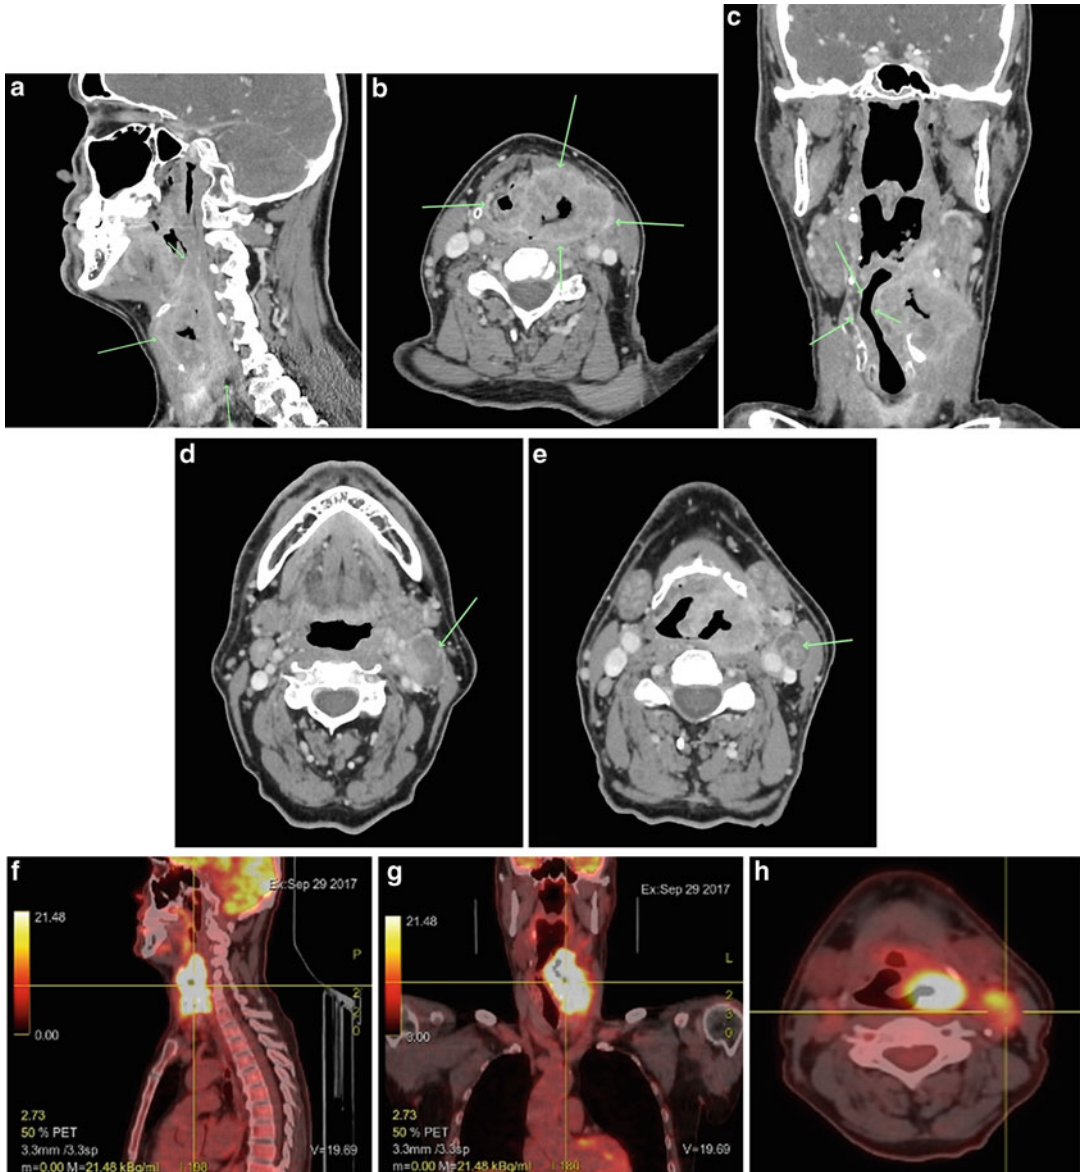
Hypopharyngeal carcinoma. Post-contrast CT sagittal (a), axial (b), and coronal (c) views show an extremely large heterogeneous and partially necrotic left-sided mass lesion (arrows). This measures approximately 10 cm craniocaudal × 6.8 cm transverse × 4.5 cm AP. Cranially, the lesion is centered in the hypopharynx and aryepiglottic fold on the left extending anterior to involve the pre-epiglottic space but spreads into the left paralaryngeal space markedly narrowing and displacing the supraglottic airway to the right. It crosses posteriorly into the right side of the hypopharynx and involves both left and right false cords. It spreads laterally to erode the posterior aspect of the left thyroid cartilage and extends
